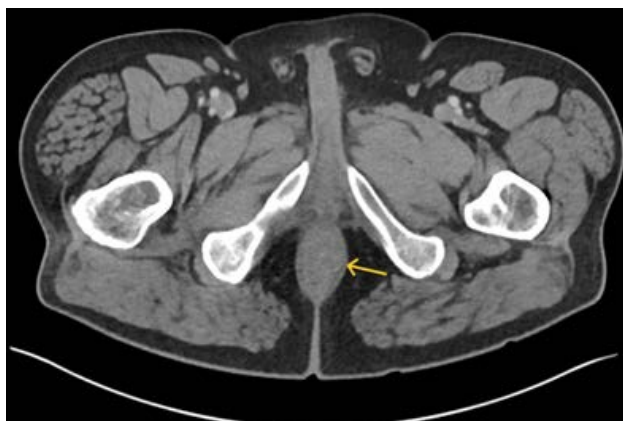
CT abdomen/pelvis with contrast showing postsurgical changes of the pelvis consistent with prior colon resections and anastomosis of distal colon with mass-like wall thickening of the lower/distal rectum consistent with a tumor without any obvious evidence of distant metastasis.
